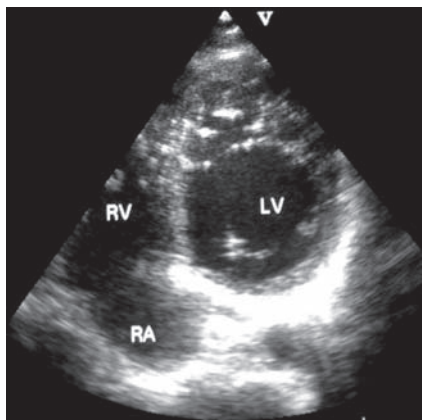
Echocardiogram in modified apical four chamber view with anterior tilt shows non-compaction of left ventricular apex. LV: left ventricle, RA: right atrial, RV: right ventricle.
